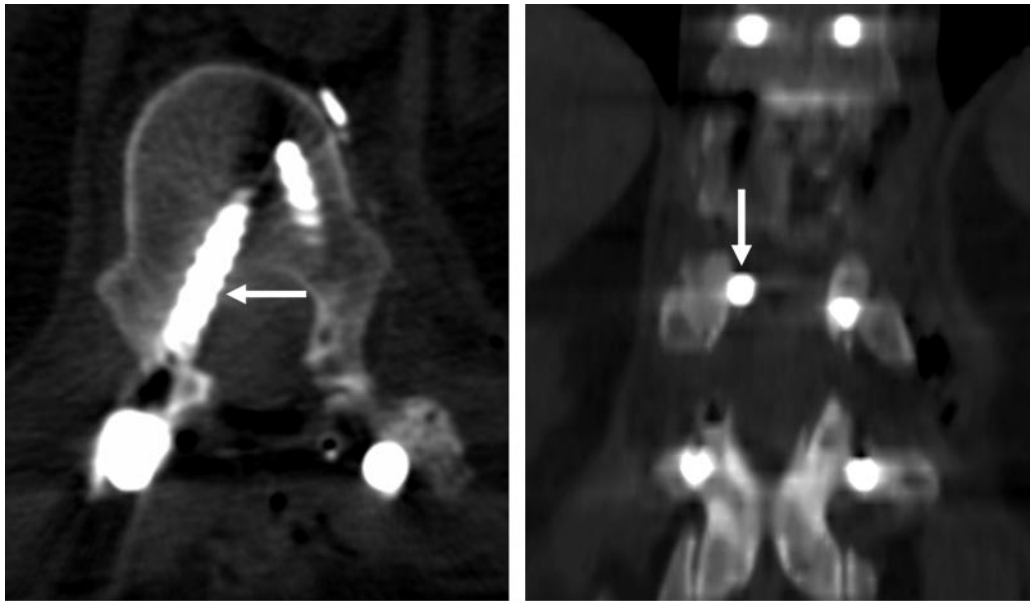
Medial deviation of a pedicle screw. Axial (a) and coronal (b) CT images show a screw that has traversed the medial cortex of the pedicle and penetrated the thecal sac (arrow), leading to a cerebrospinal fluid leak. The leak was repaired when the errant screw was removed, and a new screw was correctly positioned.
